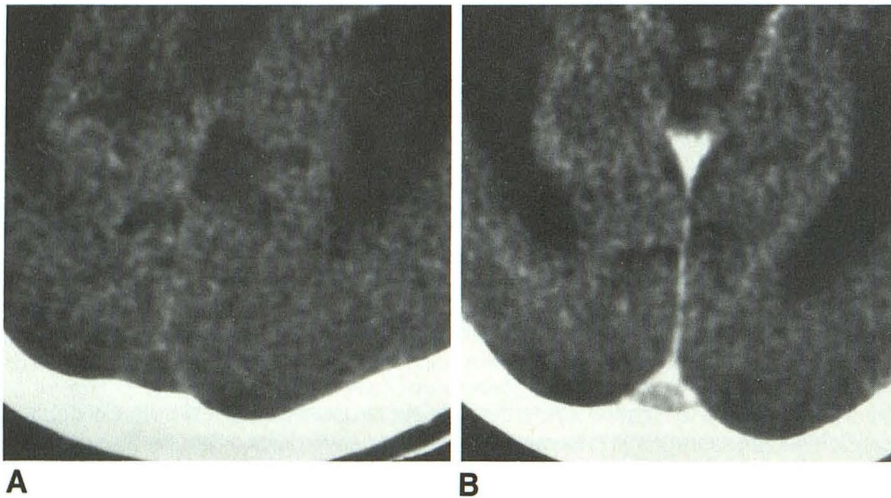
Pre- (A) and postcontrast (B) delayed CT images of superior sagittal sinus region in a patient without sinus thrombosis. Note similarity of true negative delta sign (Fig. 1B) and delayed delta sign (Fig. 2B) when only postcontrast images are compared.
